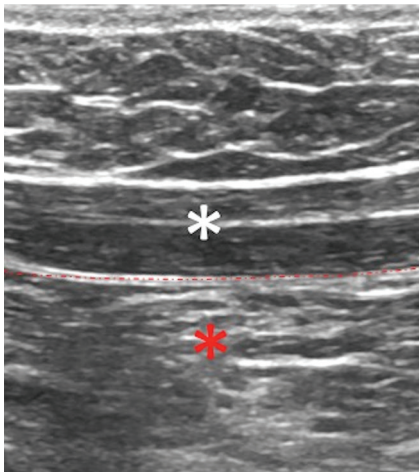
Sagittal ultrasound image of the abdominal wall showing the rectus muscle (white asterisk), transversalis fascia, and peritoneal reflection (red line) and immediately underlined by moving omental fat/bowel on real-time ultrasound (red asterisk)
